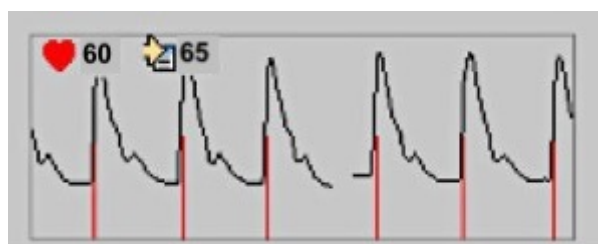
Update expected heart rate. 65 is the expected heart rate set by the radiographer and 60 is the actual heart rate of the patient detected by the scanner.
